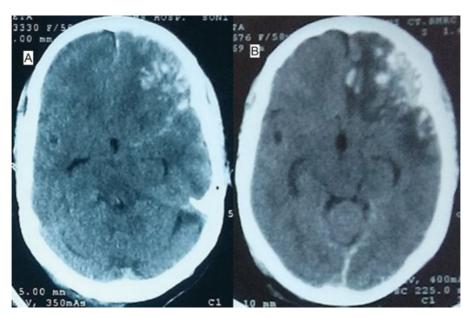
Computed tomographic (CT) scans showing contusion progression in a 58-year-old woman after road traffic accident. Patient required surgical intervention. (A) Initial CT scan. (B) CT scan after 24 hours.
